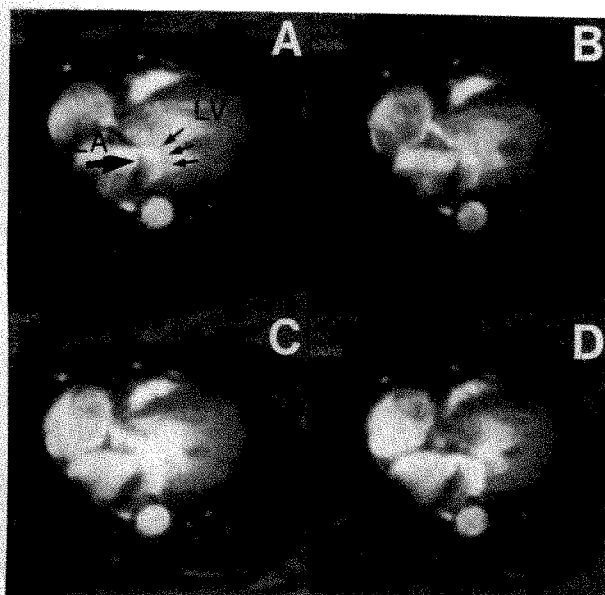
Axial cine magnetic resonance images taken from the study of a patient with moderate mitral regurgitation. Orientation is similar to Figure 2 for these systolic images. *A*, large arrow points to wedge-shaped signal void in left atrium directed posteriorly. Small arrows point to closed mitral valve leaflets. *B*, *C*, *D*, shape of signal void does not appear to change significantly in these systolic images.
